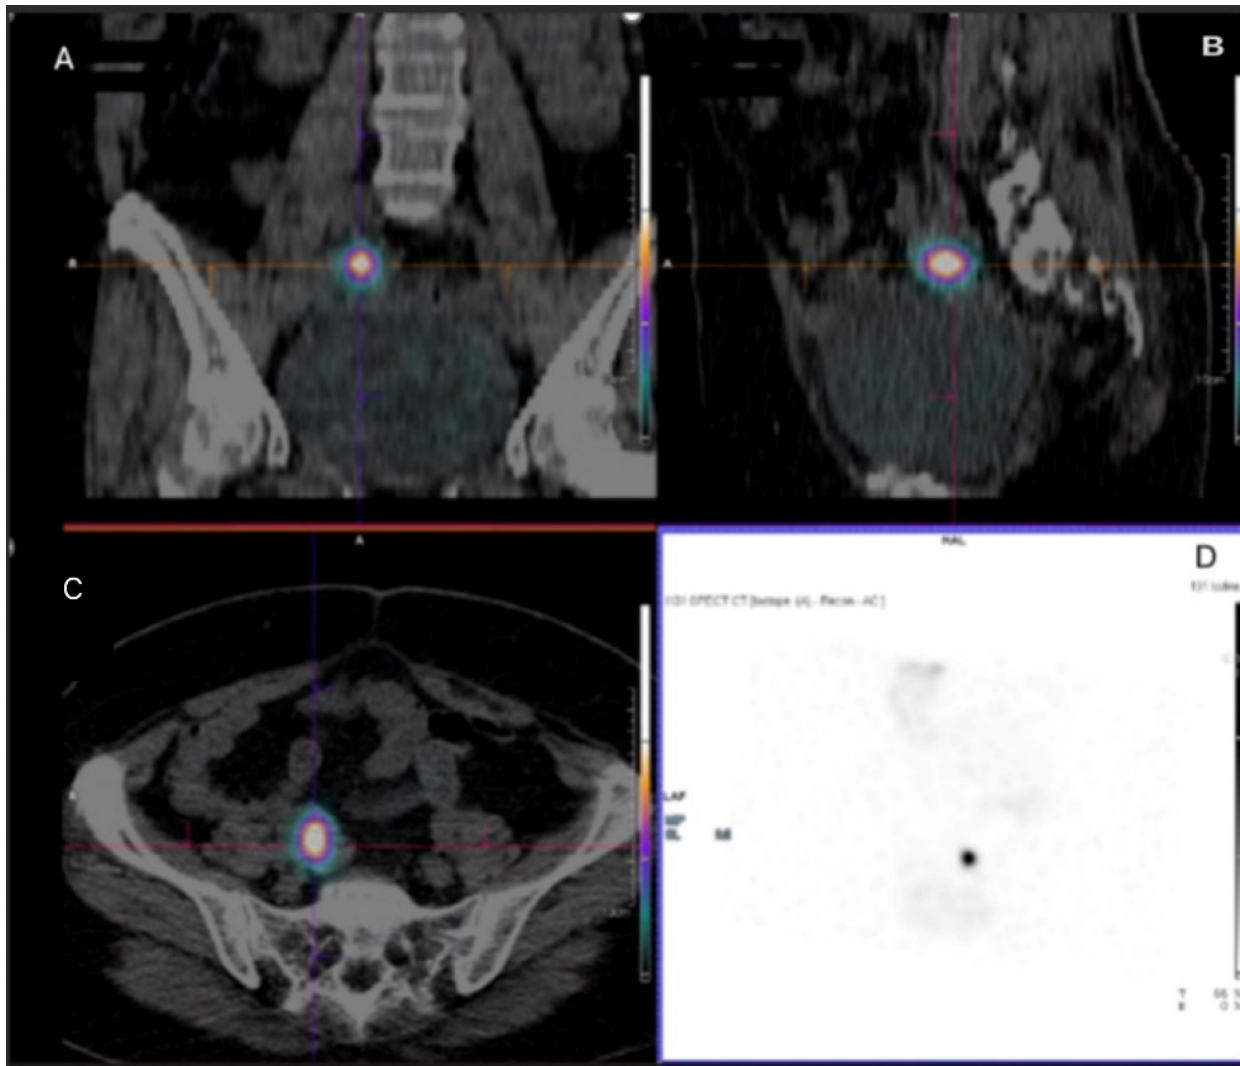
Single-photon emission computed tomography/computed tomography (SPECT/CT) pelvis. Images showing a marked increase in focal I-131 uptake in a right adnexal lesion. (A) Coronal view. (B) Sagittal view. (C) Axial view. (D) Whole body view.
